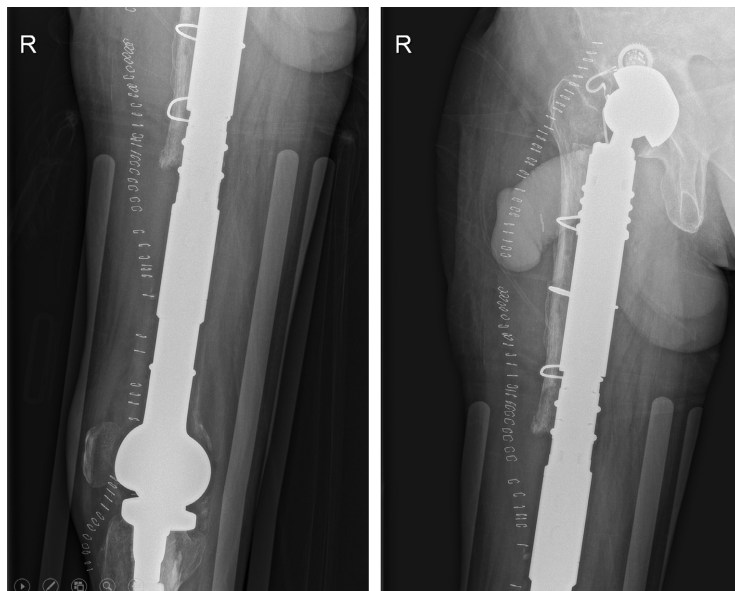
Case no. 4. Radiographs immediately after placement of the autologous tibial strut graft and femurplate.
